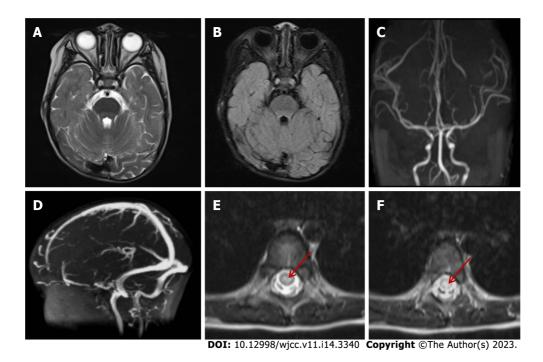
The imaging findings of brain and spinal cord magnetic resonance on day 2 after admission. A and B: T2-weighted magnetic resonance imaging and fluid-attenuated inversion-recovery imaging of the head, respectively, showed no abnormal signals in the brainstem, cerebellum, and cerebral cortex; C: Magnetic resonance arterial angiography of the head was normal; D: Brain magnetic resonance venography was normal; E and F: T2 hyperintensity in T7-10 horizontal transverse section of thoracic spinal cord (indicated by red arrow).
